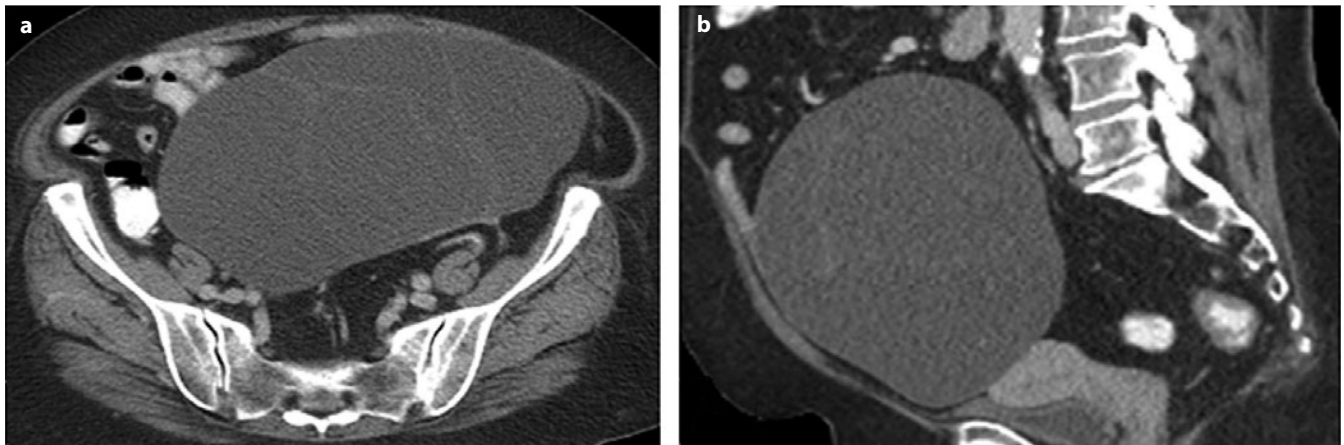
a, b. Serous ovarian cystadenoma. a Axial and b sagittal contrast-enhanced computed tomography (CE-CT) images show cystic pelvic mass with smooth margin and internal thin, regular septa, without evidence of solid mural enhancing nodules
